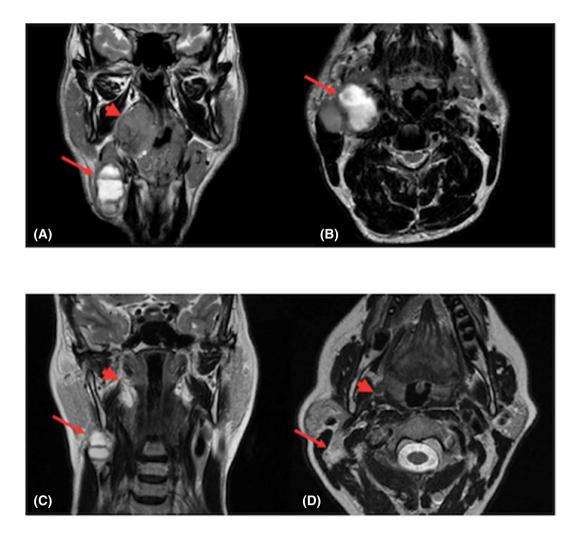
MRI T2-weighted sequences, in axial (B, D) and coronal (A, C) planes showing two HPV+ OPSCC of different size in the right platine tonsil (arrowhead), with a partially metastatic necrotic lymph node in the right IIa level (arrow). Patient number 34: copies of HPV per plasma ml were 8989.8 with voluminous primary tumor and large metastatic lymph nodes (A, B). Patient number 3: copies of HPV per plasma ml were 71.2 with small primary tumor and metastatic lymph nodes (C, D). [Color figure can be viewed at wileyonlinelibrary.com]
